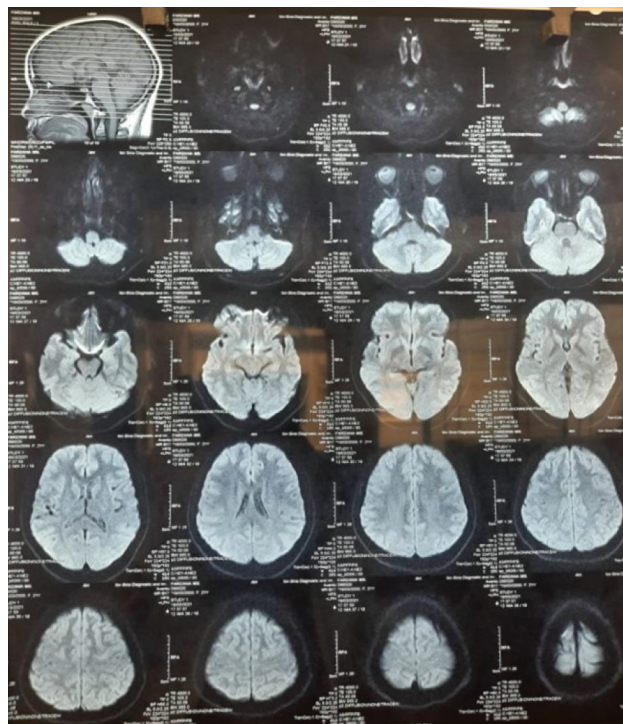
Magnetic resonance imaging (MRI) showing no abnormalities.
